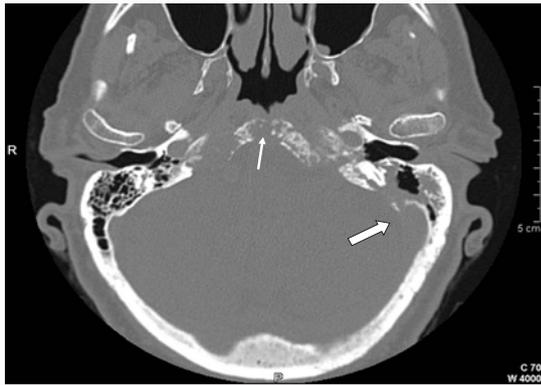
Axial high-resolution CT scan of the temporal bones evidences the metastatic lytic lesion of the clivus (arrow) and posteriorly a suspected involvement of left middle fossa dura and sigmoid sinus region (open arrow).
